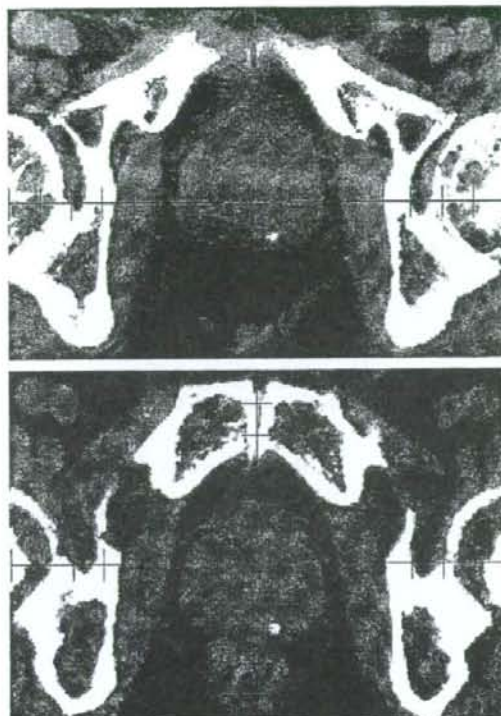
Two transverse computed tomography scan slices taken on same day before gas removal (above) and after gas removal (below), demonstrating example of prostate movement resulting from extreme distension of unstable rectal gas. Prostate was displaced 1.2 cm posteriorly after gas removal.
